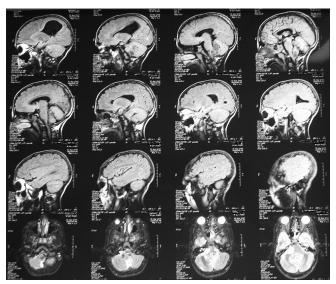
Sagittal an axial T1-weighted magnetic resonance imaging: Tumor in $\mathbf{4}^{\text{th}}$ ventricle
